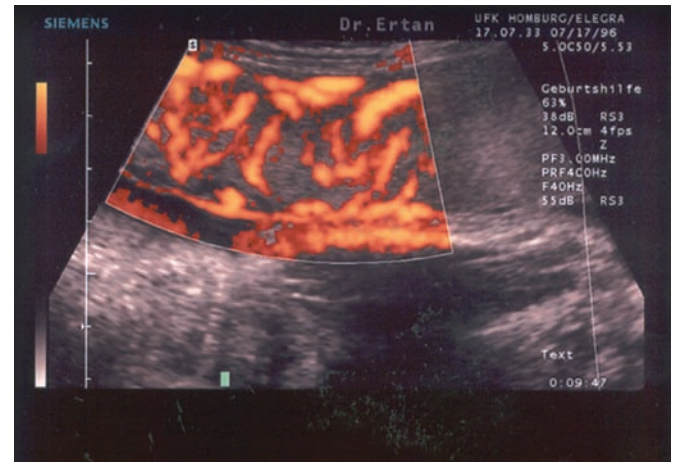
Power Doppler of arcuate and intraplacental arteries.
